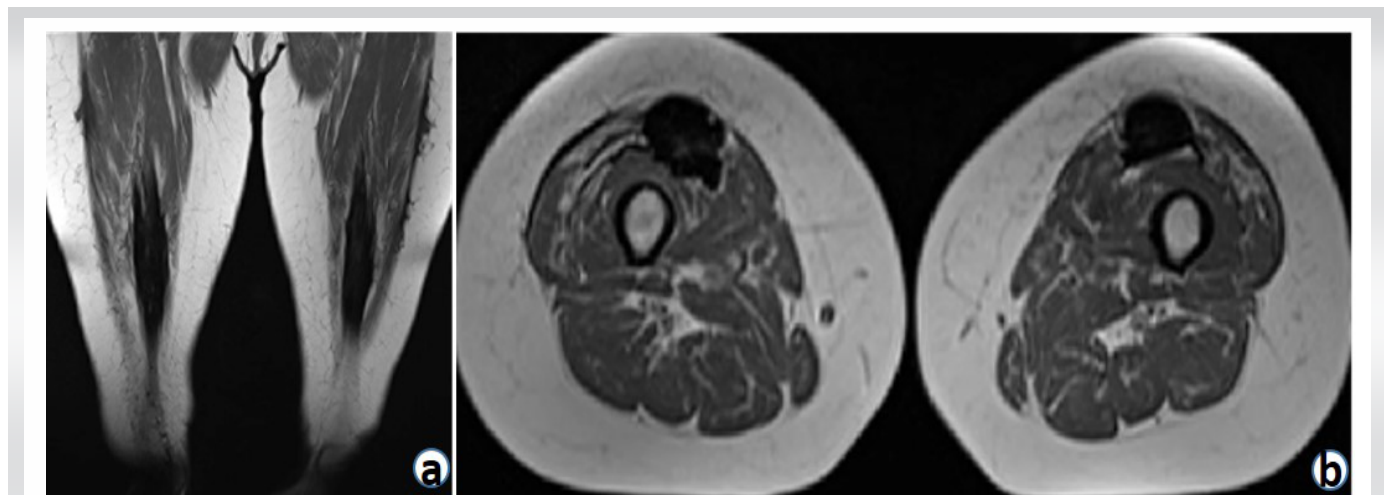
Coronal (a) and axial (b) magnetic resonance images showing the bilateral nature of this patient's calcific myonecrosis. The low T1 signal throughout the course of the rectus femoris muscles is consistent with calcification and necrosis.
